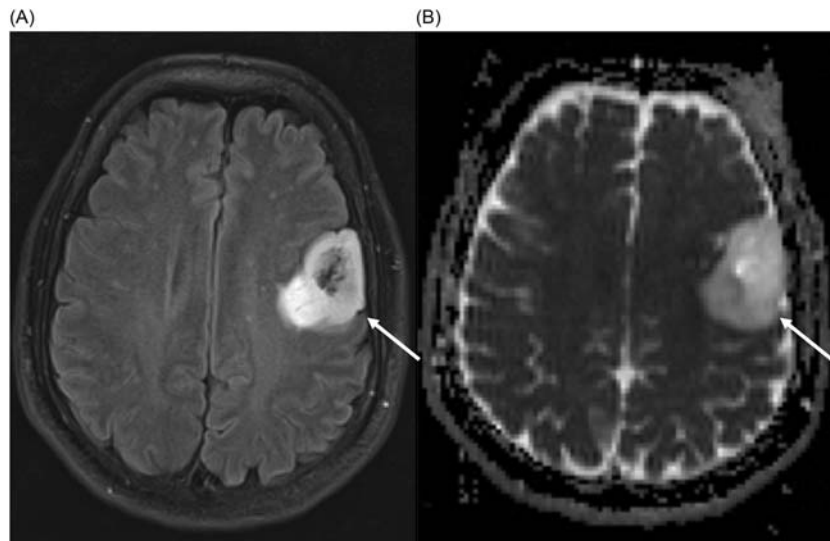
Anaplastic astrocytoma in the left cerebral hemisphere, visible on a T2-weighted MR image with free water suppression (A) (“fluid-attenuated inversion recovery,” FLAIR) and a parameter map showing the apparent diffusion coefficient ADC (B). The tumor is T2-hyperintense and shows increased water diffusion compared to the unaffected brain. Functional imaging techniques like diffusion-weighted imaging may assist in both differential diagnosis of suspicious tumors and in the delineation of the gross tumor volume for radiotherapy planning.
